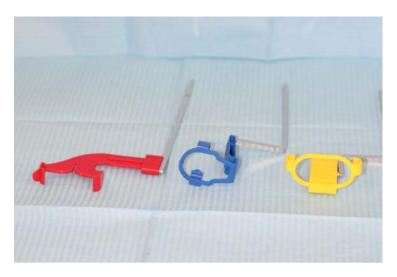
Examples of film holders. (a) Bitewing holder. (b) Anterior periapical holder. (c) Posterior periapical holder
